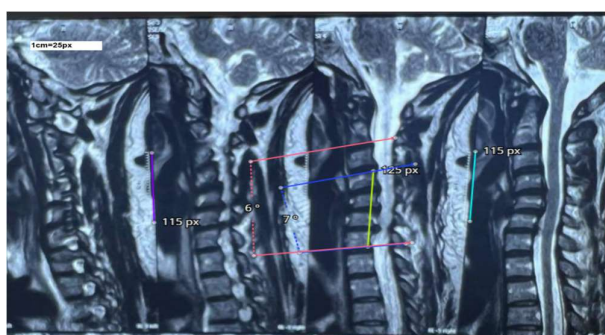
Case 3 Pre operative MRI T2 MRI sagittal view of cervical vertebrae.
